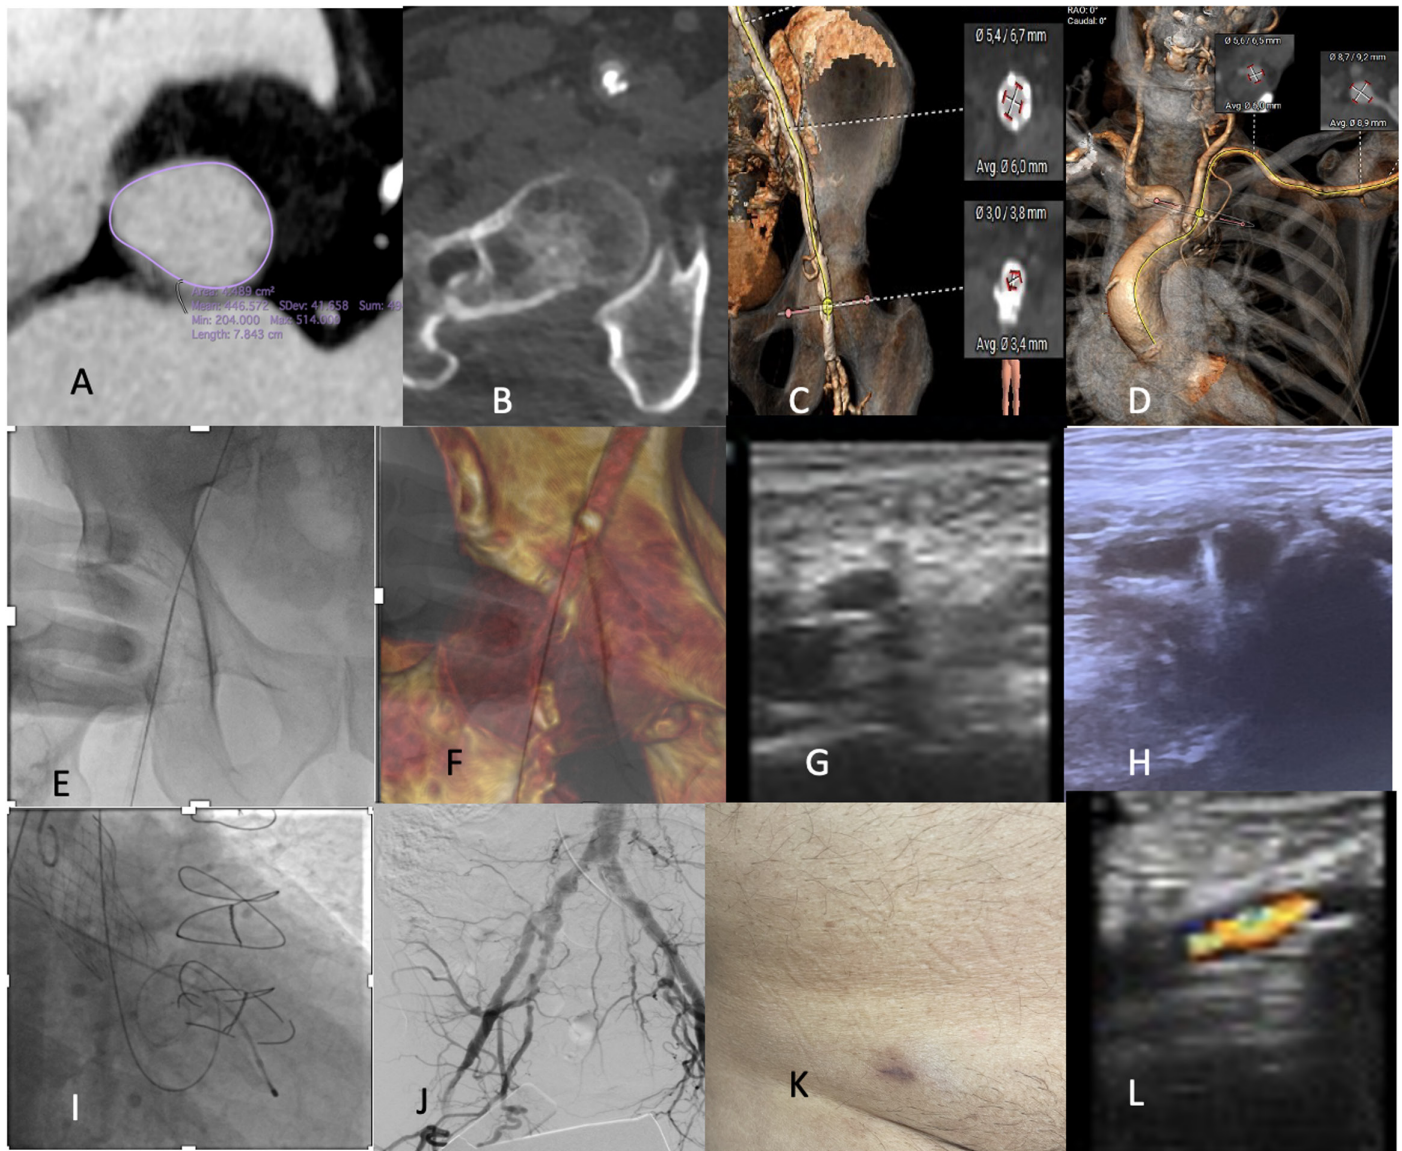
A: Aortic annulus calculations. B: Calcific severe stenosis on right common femoral artery. C: The stent in the left common femoral artery with a significant restenosis having a minimum diameter of 3.0 mm. D: The right subclavian-aortic arch angle was 270 degrees. E, F, G, H: A transiliac puncture was performed under ultrasound and CT fusion guidance. I: A Medtronic Evolute R 29 mm valve was implanted. J: Control DSA. K, L: Entry side controls.
